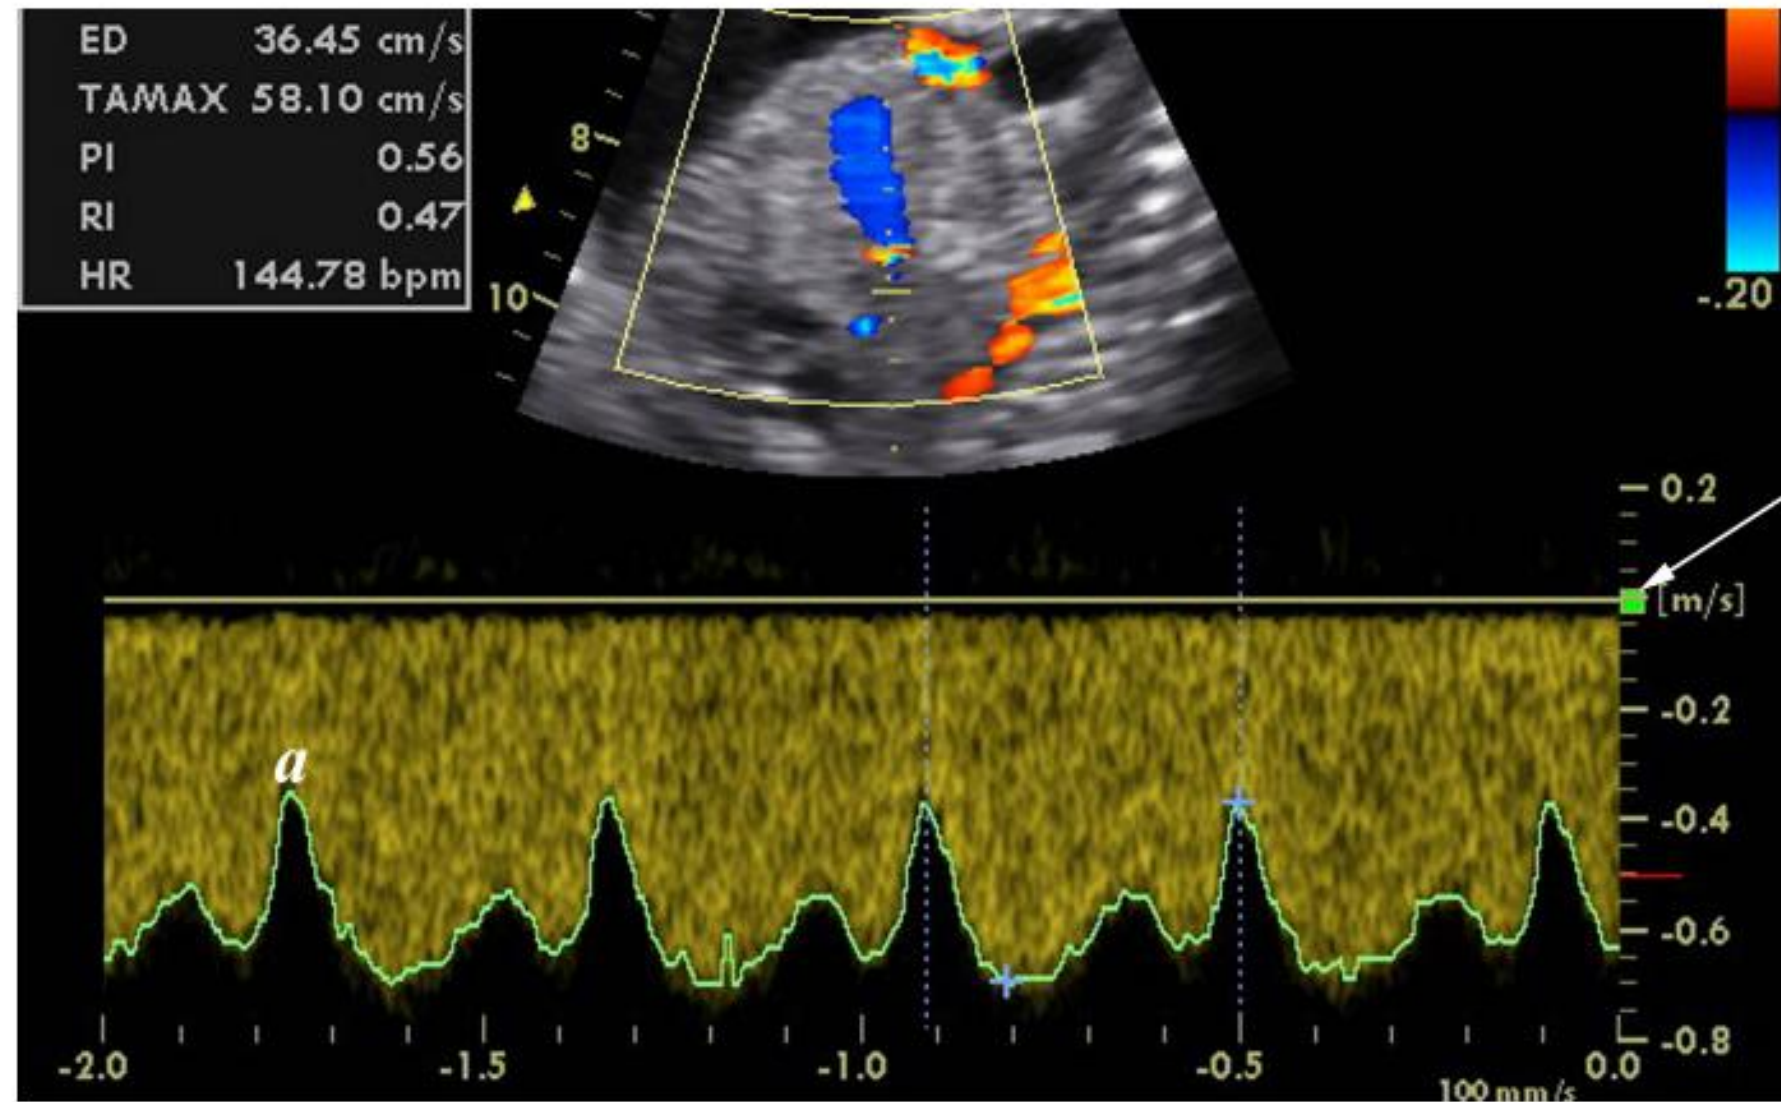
Ductus venosus Doppler recording with sagittal insonation aligning with the isthmic portion, without angle correction. The low-velocity vessel wall filter (arrow) does not interfere with the a-wave (*a*), which is far from the zero line. A high sweep speed allows detailed visualization of variation in velocity.
